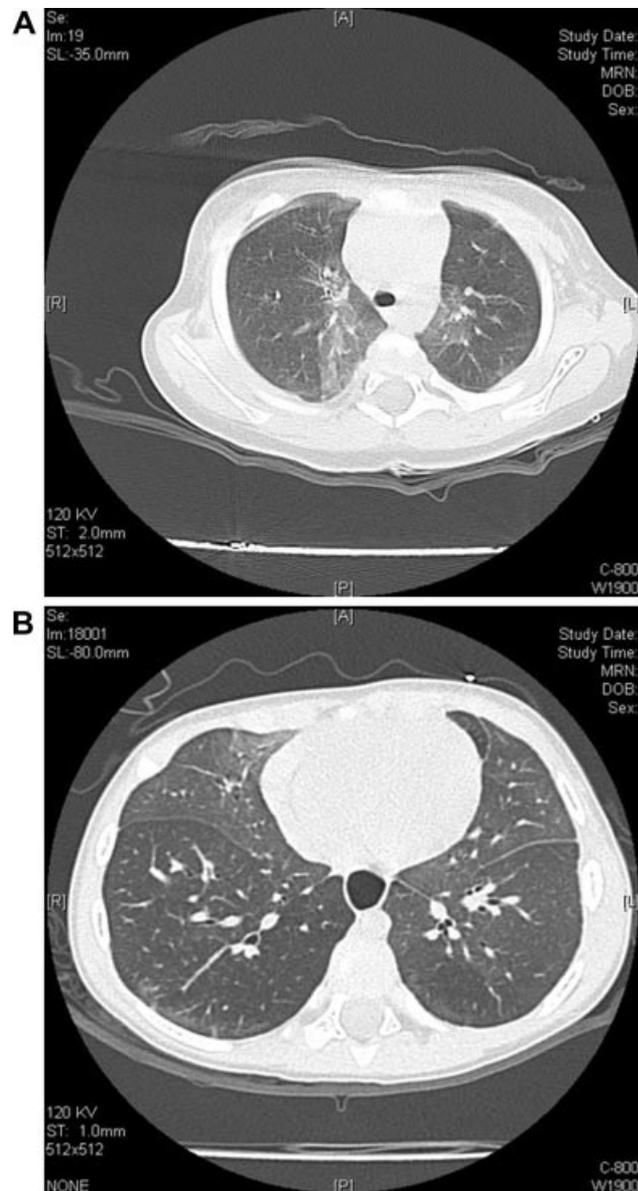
Examples of characteristic chest HRCT findings in NEHI. A: This image is from affected Sibling 1 in Family 1. Findings include ground-glass opacities found most prominently in the medial parts of the RUL and LUL. B: This image is from affected Sibling 2 in Family 1. Findings include ground-glass opacities found most prominently in the RUL and lingula, and additionally in the RML and LLL.
